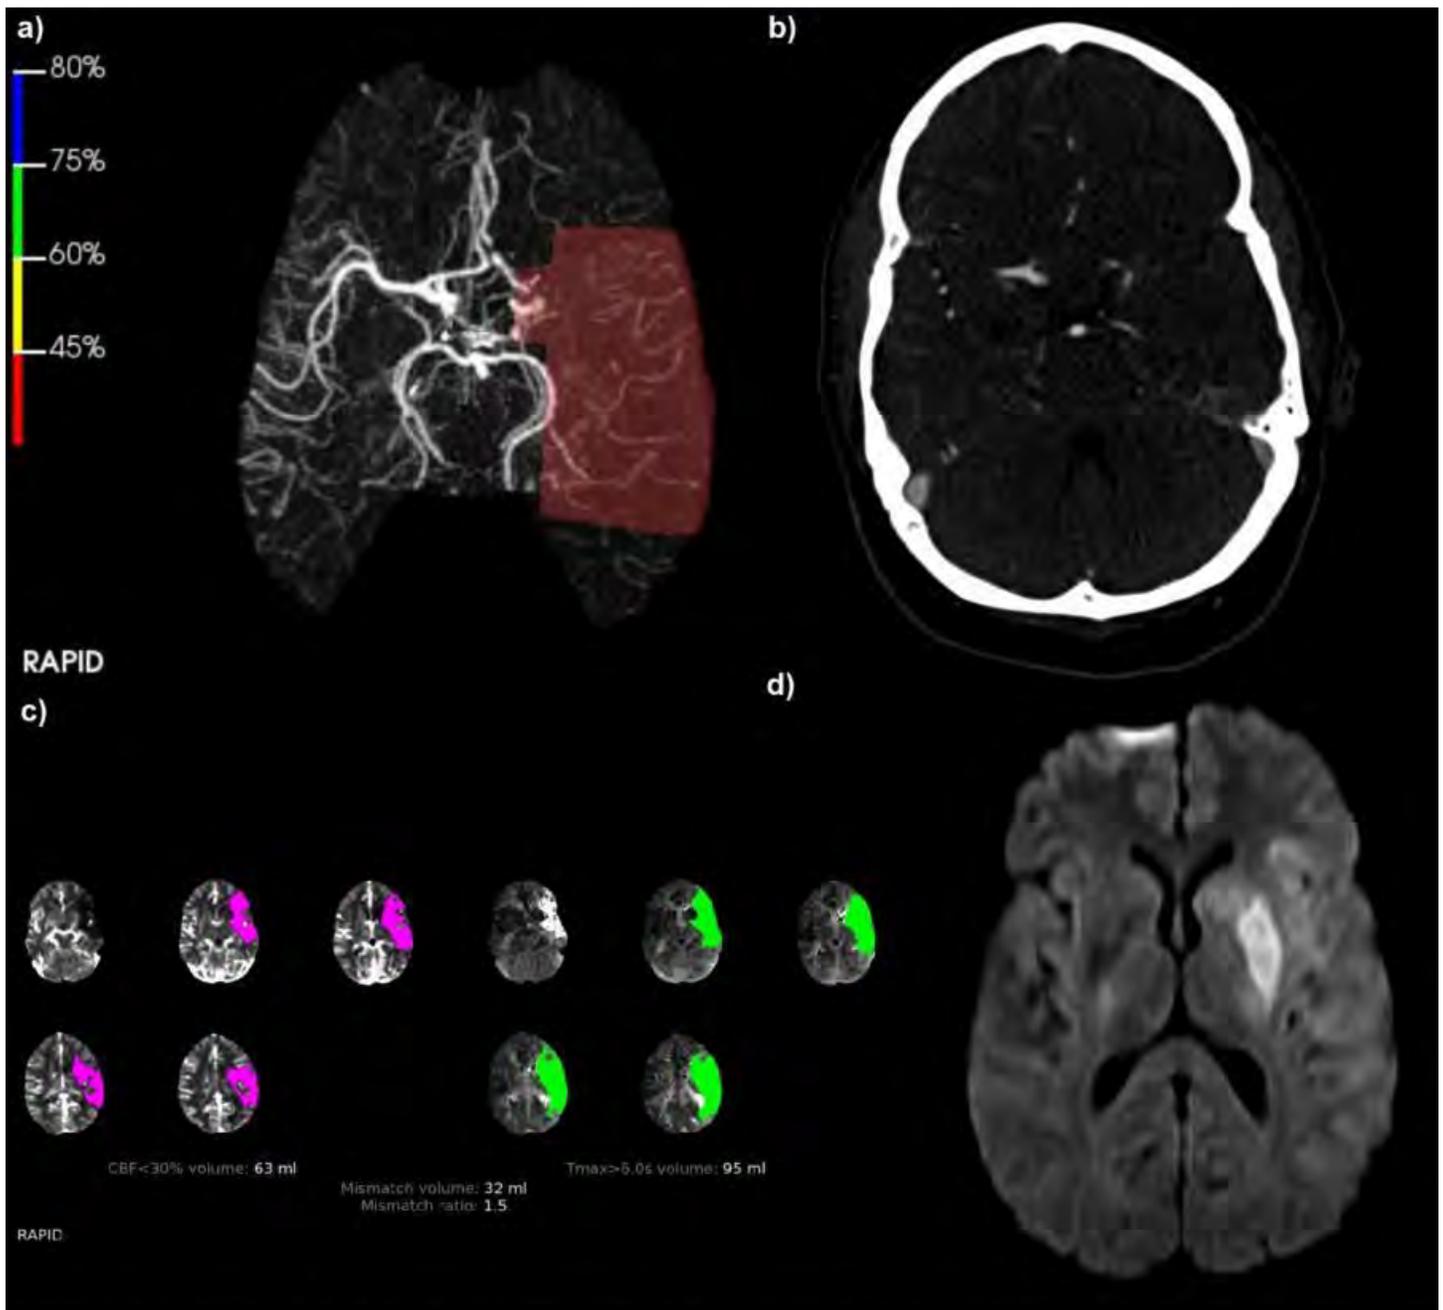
a) Rapid CTA output showing decreased vessel density in a Left ICA/MCA distribution. b) CTA showing occlusion of the left ICA terminus. c) Rapid CT perfusion output showing decreased cerebral blood flow and delayed perfusion in the left MCA territory. d) MRI after thrombectomy showing infarct in the left putamen.
